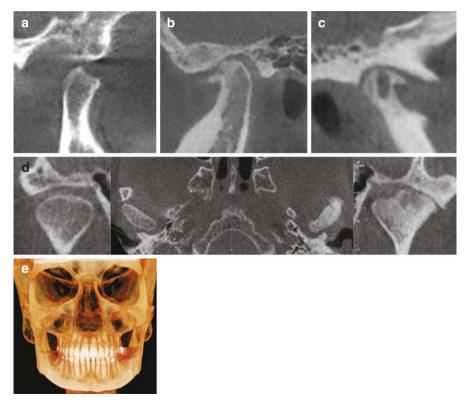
CBCT reformats show (a) active DJD, with an erosion noted on the articular surface, (b) stable DJD with flattening and sclerosis of the articular surfaces and anterior osteophyte formation, (c) stable DJD with a large subchondral bone cyst connecting with the articular surface, (d and e) minimal mandibular asymmetry in unilateral adult DJD
